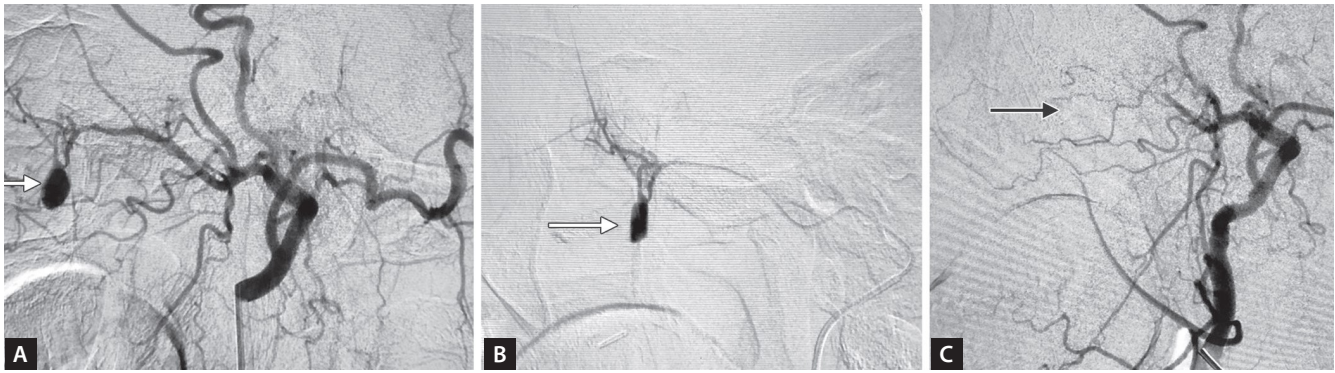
to D: A 57-year-old male postsurgery/chemotherapy/radiotherapy for right head and neck malignancy. He is presented in emergency with active fresh pulsatile bleed from a neck wound. (A) CT angiography image showing pseudoaneurysm (white arrow) arising from the occipital branch; (B) Digital subtraction angiogram (DSA) confirming the pseudoaneurysm (white arrow); (C) DSA after coiling (black arrow) showing no filling of pseudoaneurysm as well as the occipital branch; (D) Clinical wound picture with area of bleed (black arrow).
